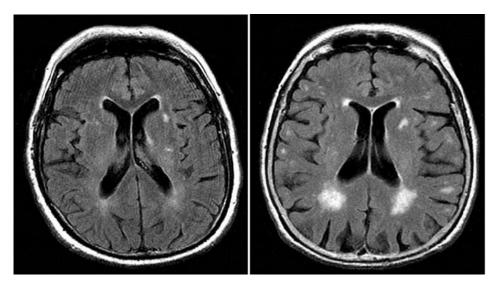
MRI Brain Scans Showing Structural Changes Associated with Dementia
